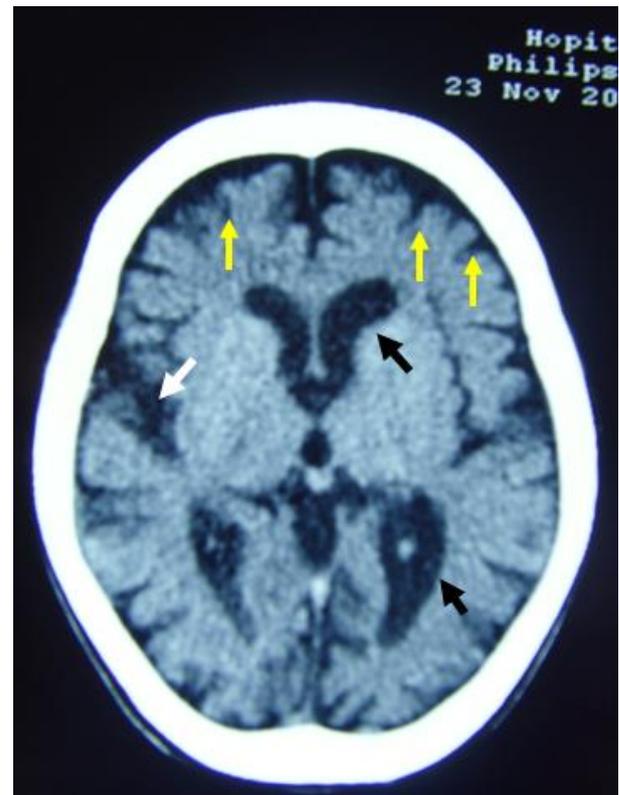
Cerebral CT in axial section showing widening of sylvian valleys (white arrow) and cortical sulci (yellow arrows) indicative of cortical atrophy, and ventricular widening indicative of subcortical atrophy (black arrows).
